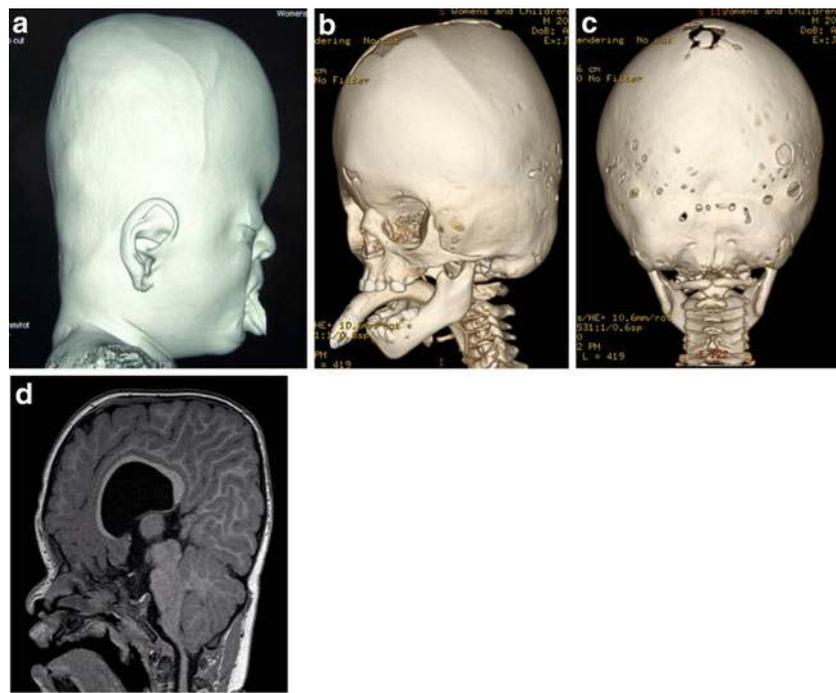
Images of a child presenting at the age of 2 with Apert syndrome. a Soft tissue CT reconstruction demonstrating turribrachicephaly, orbital proptosis, and midfacial hypoplasia. b 3-D CT reconstruction demonstrating turribrachicephaly, bilateral coronal suture synostosis, midfacial hypoplasia, and shallow orbit. c 3-D CT reconstruction from posteriorly demonstrating bilateral lambdoid suture synostosis, convolutional
